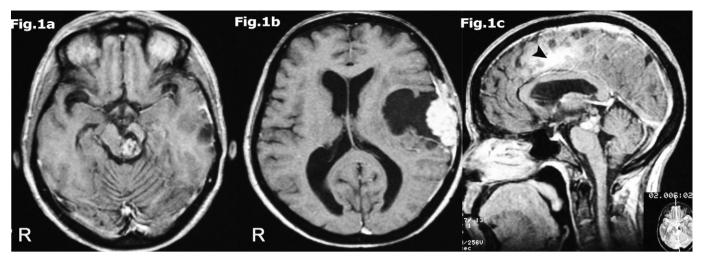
Preoperative axial (a, b) and sagittal (c) T1-weighted enhanced MRI revealed a cavernoma in the left midbrain tegmentum with subacute intralesional hemorrhage and a hemosiderin ring that extended to the left cerebral peduncle. The cavernoma was associated with a prerolandic left parasagittal meningioma, whose dural implant is shown in the picture (arrowhead), and a left temporal convexity meningioma that excluded the sylvian fissure cistern.
